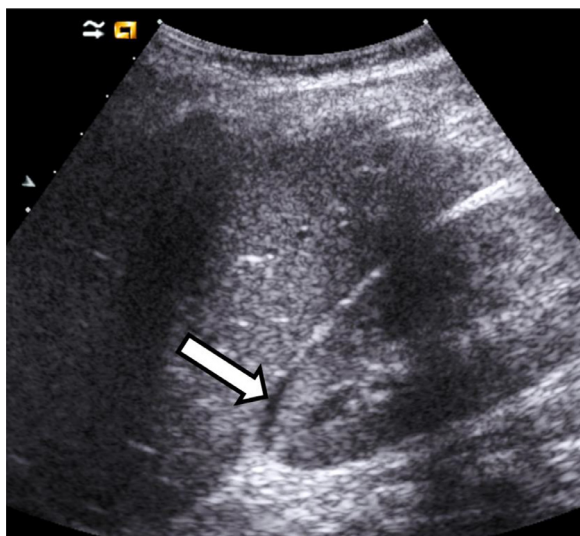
Ultrasound image of the right kidney in a 15-year-old male adolescent following a bicycle accident showing a small posttraumatic subcapsular haematoma (arrow) defined as grade I injury.
